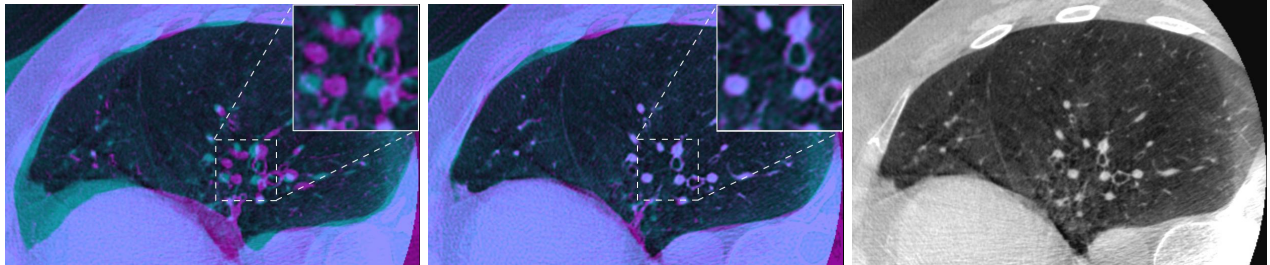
Axial view of the lung. Left: CT-CBCT image overlap after rigid registration. Middle: CT-CBCT image overlap after non-rigid registration. Right: target intraoperative CBCT image.
